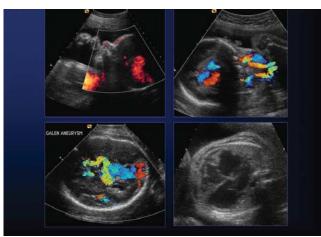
Sonographic findings associated with fetal vein of Galen aneurysm. Highly vascular intracranial lesion is seen (left upper, lower). Neck vessels are grossly dilated (right upper). Cardiomegaly (bottom right) secondary to high output cardiac failure is present. Associated polyhydramnios and hydrops can be seen in severe cases.
